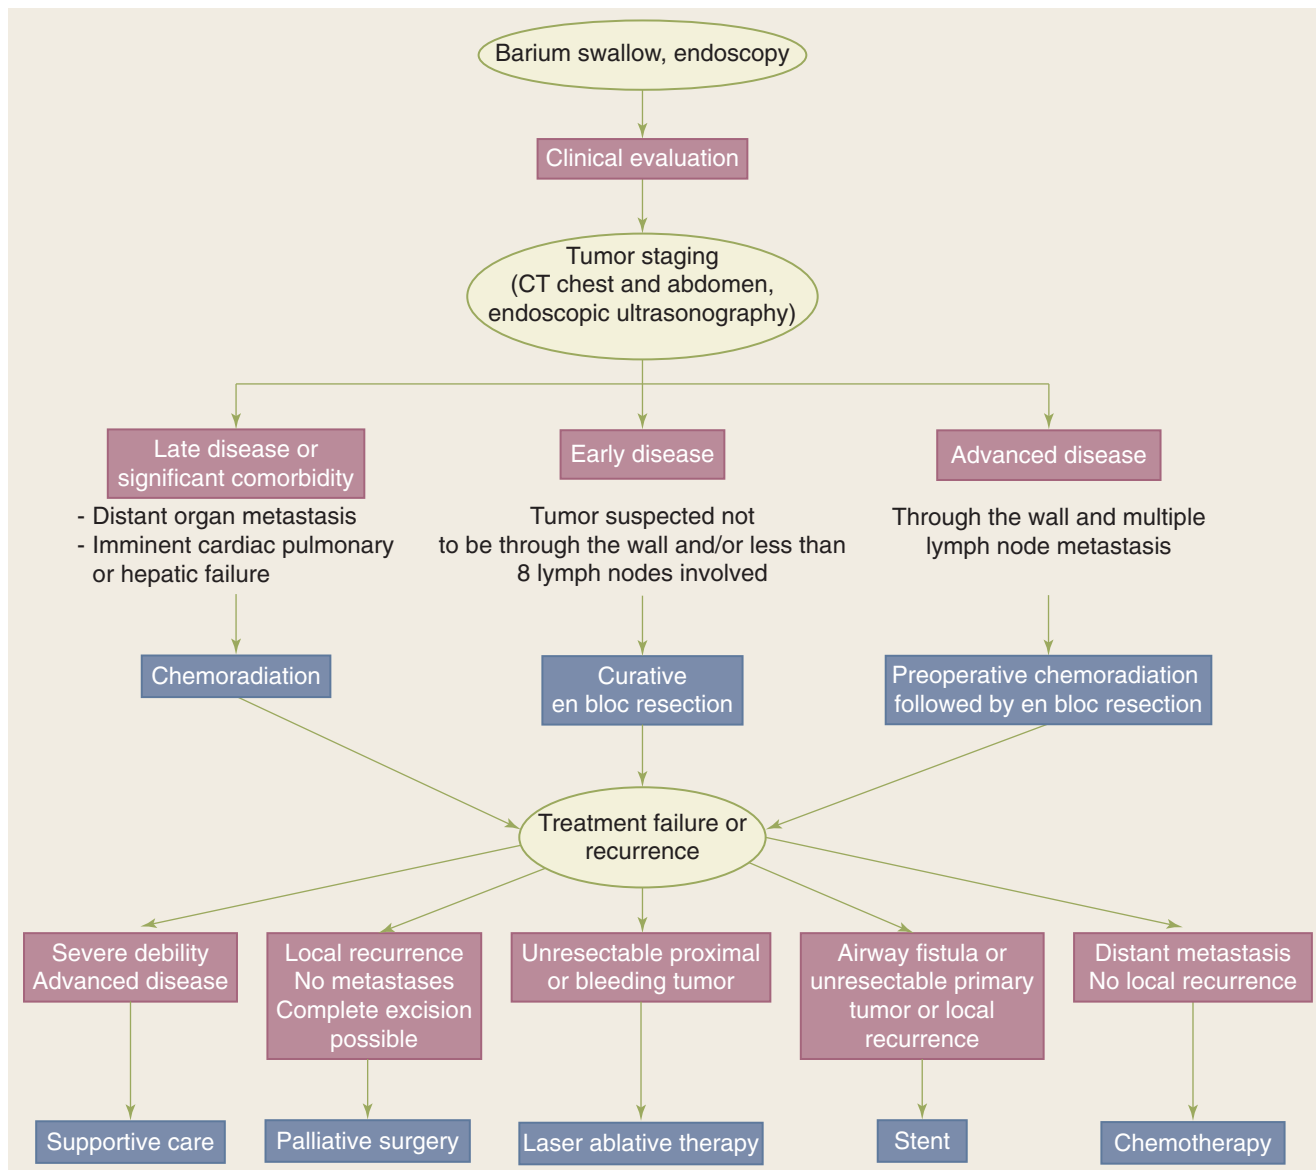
Suggested global algorithm for the management of carcinoma of the esophagus. CT = computed tomography.
